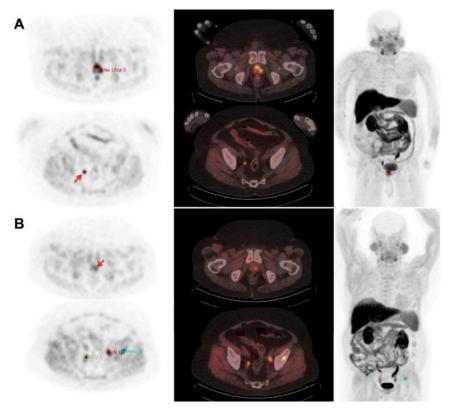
Heterogeneous response on serial ¹⁸F-fluorocholine PET/CT PET (left column), PET/CT (middle column), and maximum intensity projection (MIP) (right column) images from a 64 year old patient receiving sipuleucel-T. Pre-treatment images show abnormal activity in the prostate gland (red contour, top row A). PET/CT obtained 60 days after starting treatment shows significant decline in prostatic activity (arrow, top row B) but new abnormal activity in a left iliac lymph node and the ilium (red and blue contour, bottom row B). Net MATV increased from 32.5 to 34.0 cm³ and PSA increased from 35.0 to 47.9 ng/mL. PSA progression was confirmed 3 months later (PSA = 65.1 ng/mL). Excreted tracer in the right ureter was not confused as a lesion (arrow in bottom row A and yellow contour in bottom row B).
